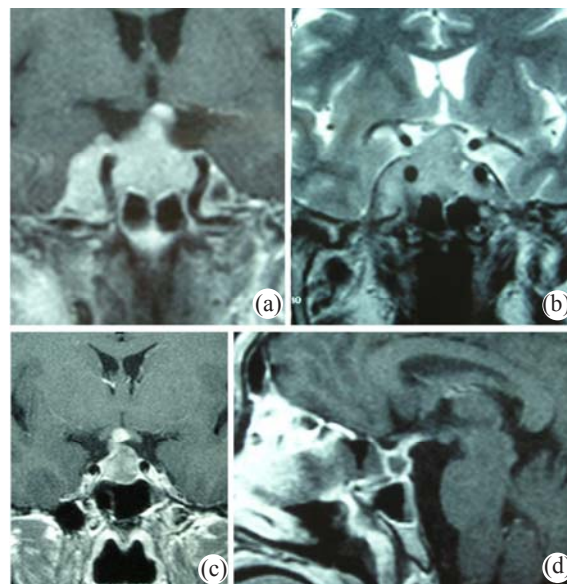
MR images obtained through the pituitary gland show diffuse enlargement and enhancement of the pituitary gland. The gland shows in a pyramidal shape extending to hypophysial stalk from the sellar base. MR images also note the presence of enhanced mucosa in the bilateral sphenoid sinus and enhanced meninges around the sella. (a) Case 1: T1-weighted coronal (450/15/4, repetition time (TR)/echo time (TE)/excitations) MR image; (b) Case 1: T2-weighted coronal (4000/90/3; echo train length, 8) MR image; (c) Case 2: contrast-enhanced T1-weighted coronal (450/15/4) MR image; (d) Case 2: follow-up one year, postoperative MR examination, contrast-enhanced T1-weight sagittal (450/15/4) MR image
